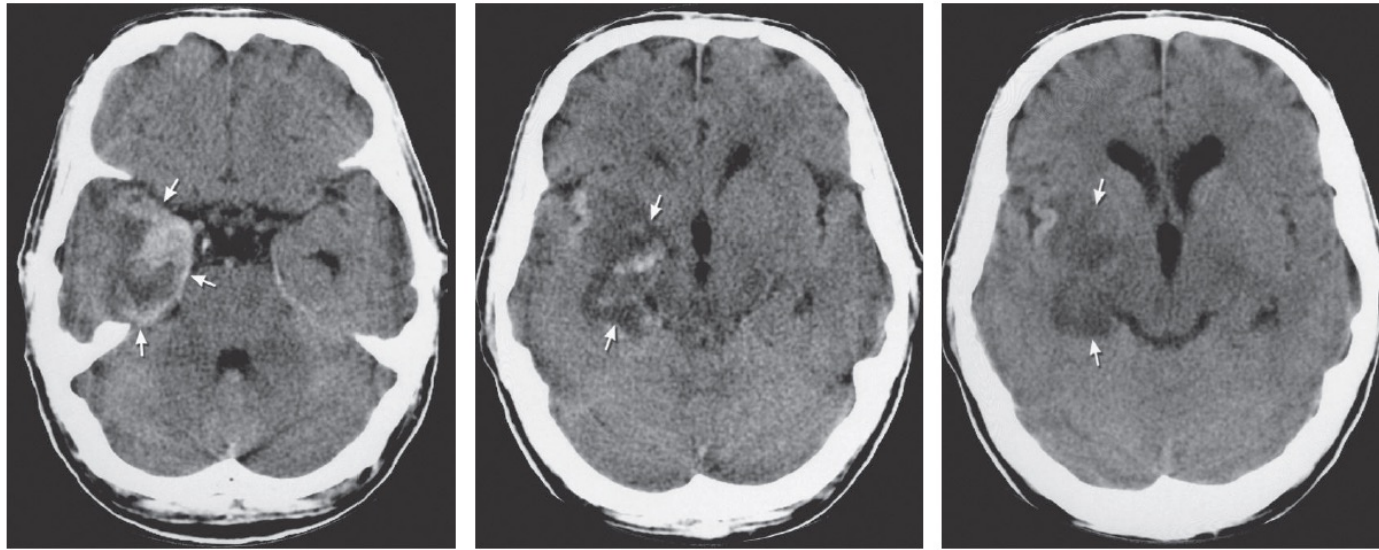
Herpes simplex encephalitis. Computed tomographic scans showing unilateral swollen, hypodense, and partly hemorrhagic temporal lobe lesion from herpes simplex encephalitis (*arrows*).
